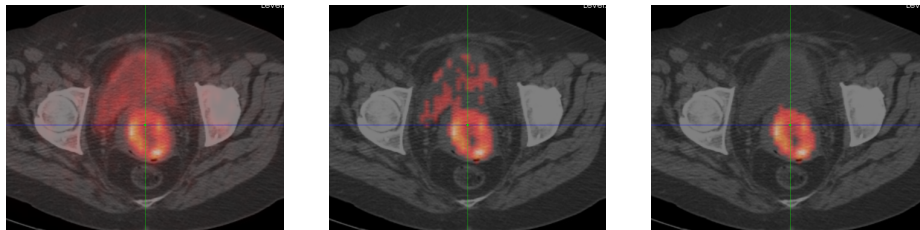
Example of metabolic tumor region segmentation in PET1. (left) PET/CT1 with a high bladder uptake. (middle) LTR after RGAT. (right) MTR1 after the FGMC.
